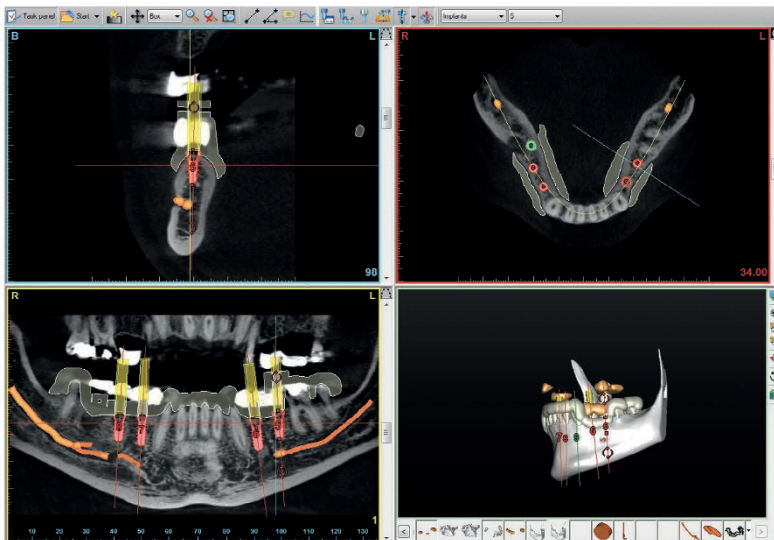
CBCT Simplant planning software used to plan implant placement in a patient with hypodontia
